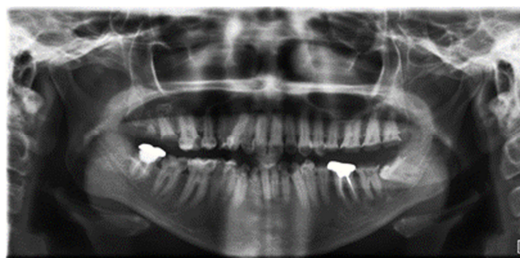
An orthopantomogram showing coronal radiolucency involving enamel, dentin and pulp were present in all teeth. Also, radio opacity involving the coronal part of the tooth extending till the apical one- third with respect to 36 and 47 suggestive
